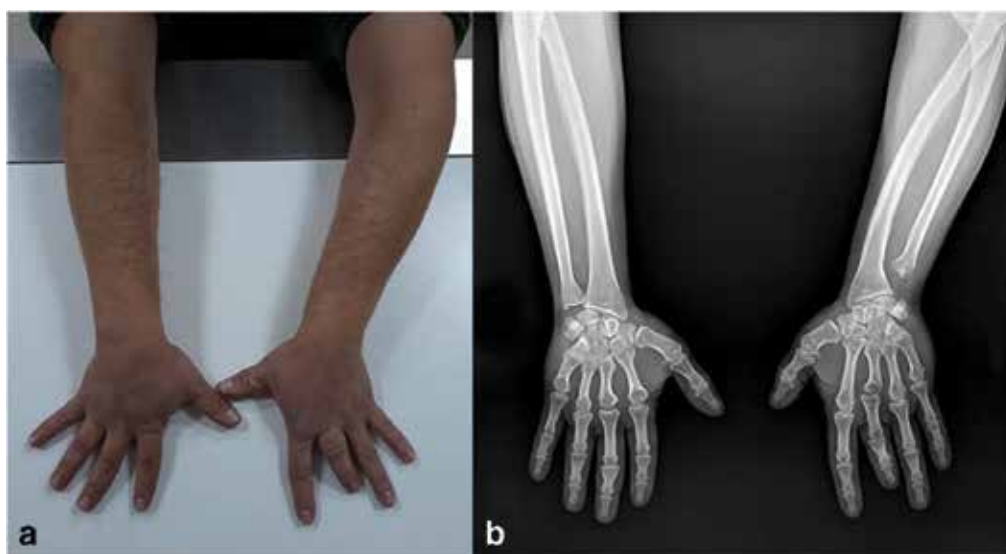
a Clinical photograph and b anteroposterior radiograph of both forearms, including both hands, show that the right forearm and hand are normal, whereas the third digit of the left hand is short. Partial absence of the distal portion of the left ulna, and left radial bowing is evident on the radiograph (b).
